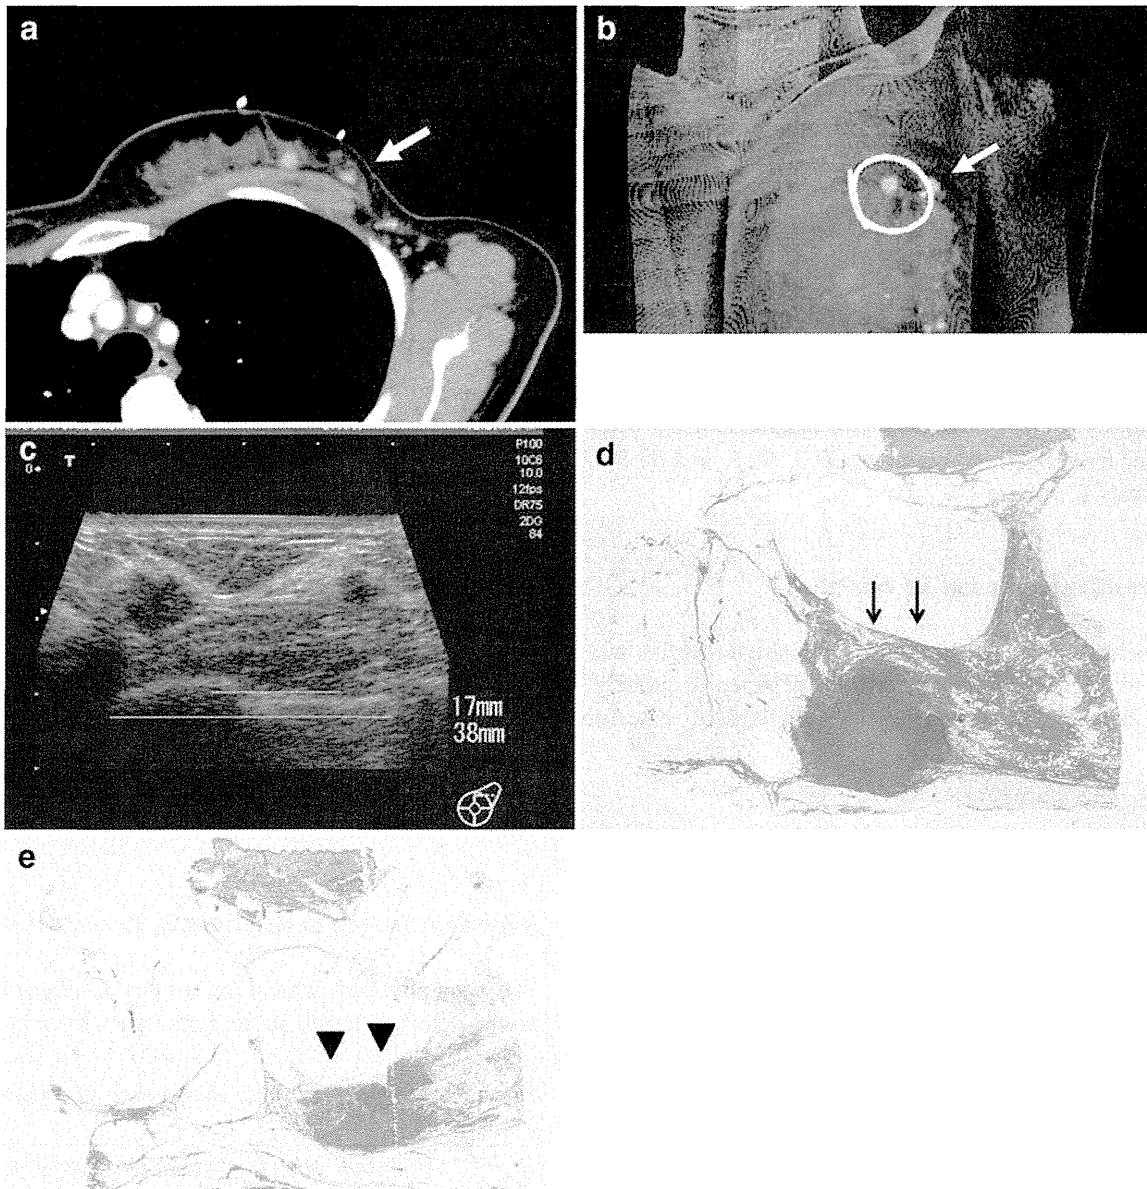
An instance in which CT successfully affected surgical management. a CT image showing an enhancing lesion (*arrow*) lateral to the main tumor which suggested that it was located outside the planned resection line. The angiocatheter can be seen on the skin demarcating the pre CT planned resection line. b Maximum intensity projection image of the right breast. The *white line* indicates the surgical line that was originally planned. c Second look
